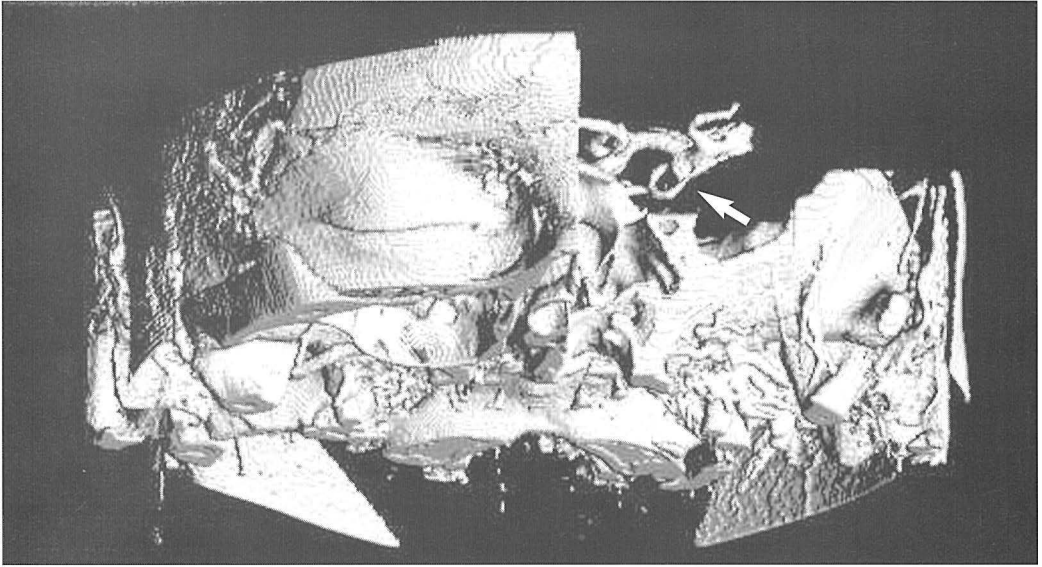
CT angiogram, volume rendering technique, anteroposterior view, demonstrates an aneurysm at the bifurcation of the middle cerebral artery and its relationship to the middle cerebral artery branches (arrow).
